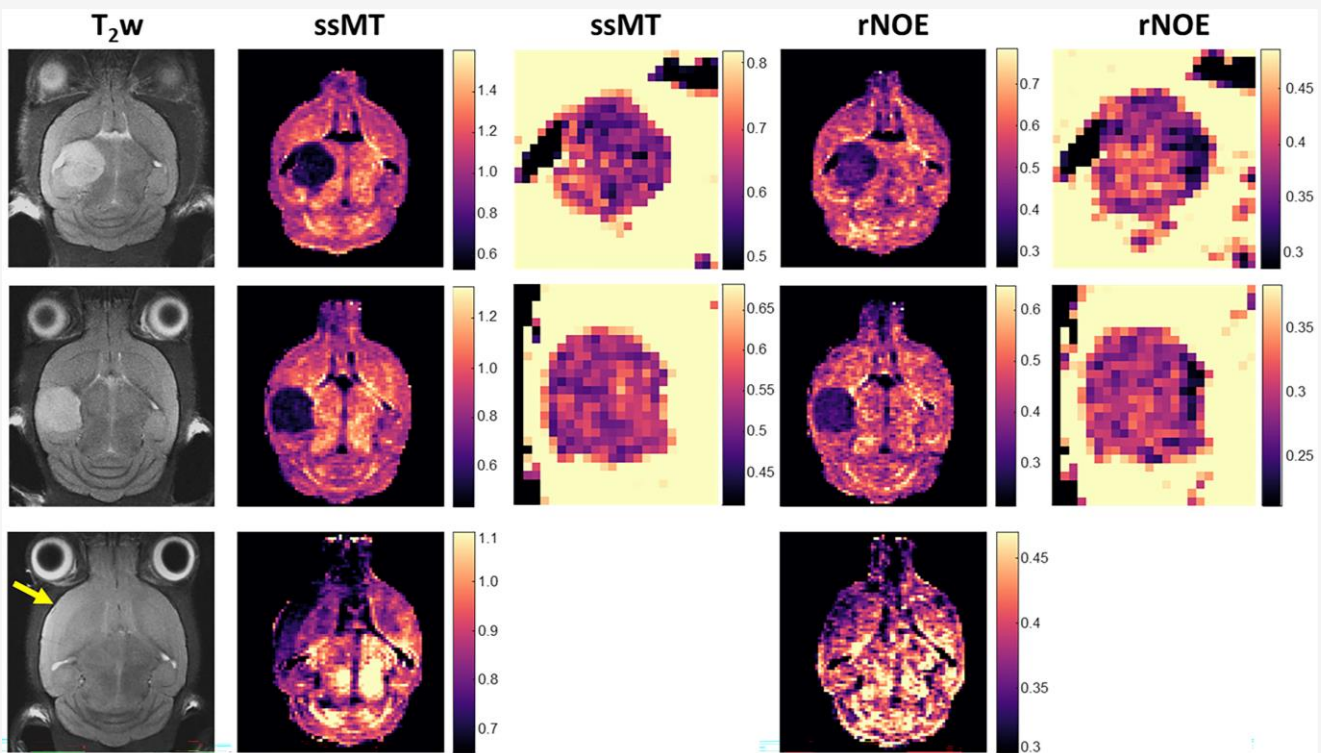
T_2w MRI of three orthotopic PDHGG xenograft models alongside maps of CEST contrasts relating to immobile (ssMT) and mobile (rNOE) macromolecules, which show clear tumour delineation for two models (top and middle rows). Localised ssMT and rNOE maps scaled using a narrower dynamic range show the heterogeneous contrast present within these tumours. CEST maps of a diffusely growing tumour (bottom row) show more image contrast in the region of tumour growth (arrowed) than the anatomical T_2w image.
